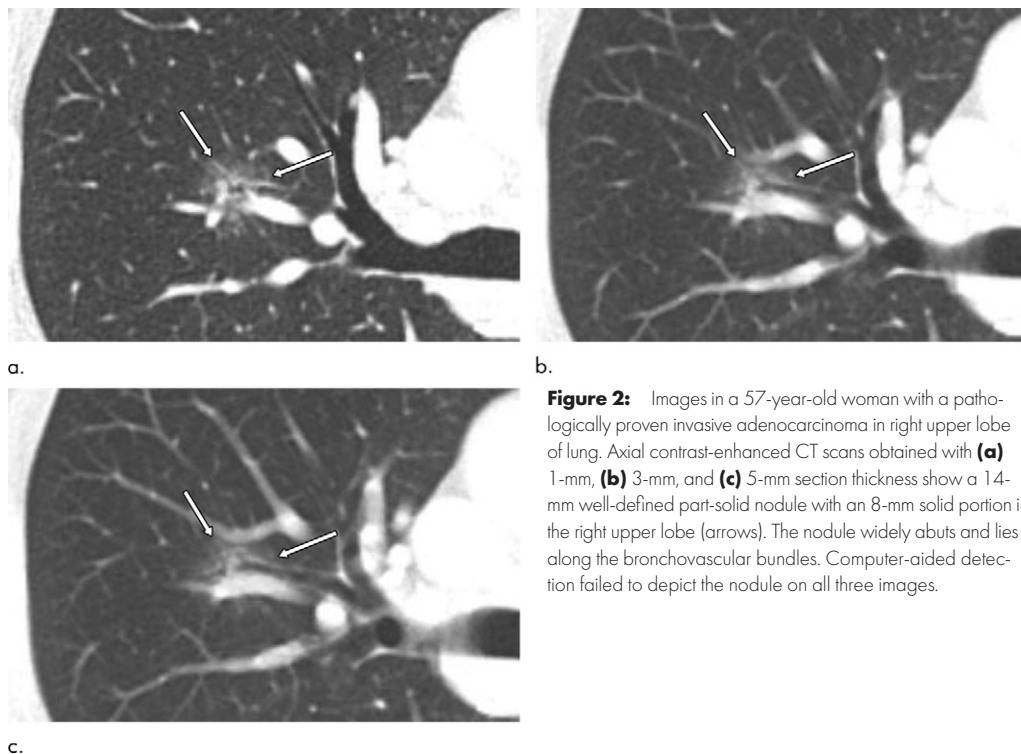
Images in a 57-year-old woman with a pathologically proven invasive adenocarcinoma in right upper lobe of lung. Axial contrast-enhanced CT scans obtained with (a) 1-mm, (b) 3-mm, and (c) 5-mm section thickness show a 14-mm well-defined part-solid nodule with an 8-mm solid portion in the right upper lobe (arrows). The nodule widely abuts and lies along the bronchovascular bundles. Computer-aided detection failed to depict the nodule on all three images.
